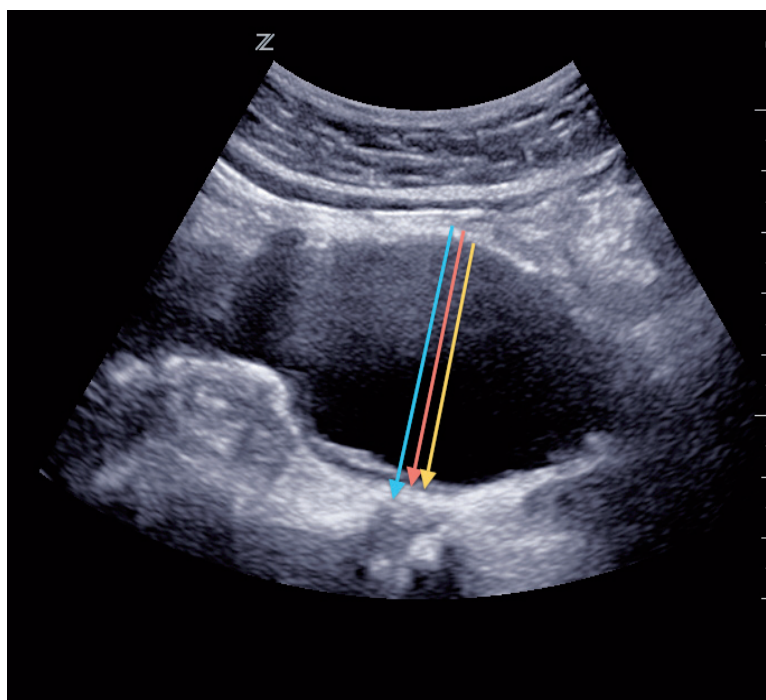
Different approaches to measure aortic diameter with ultrasound. Blue OTO, Red LELE, Yellow ITI
